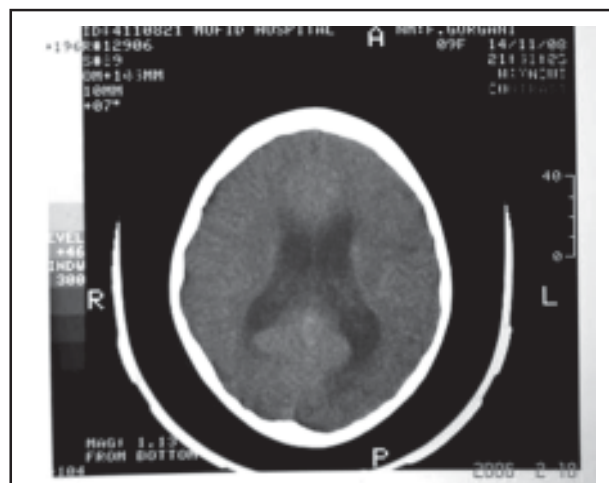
Brain CT revealed mild communicating hydrocephaly
